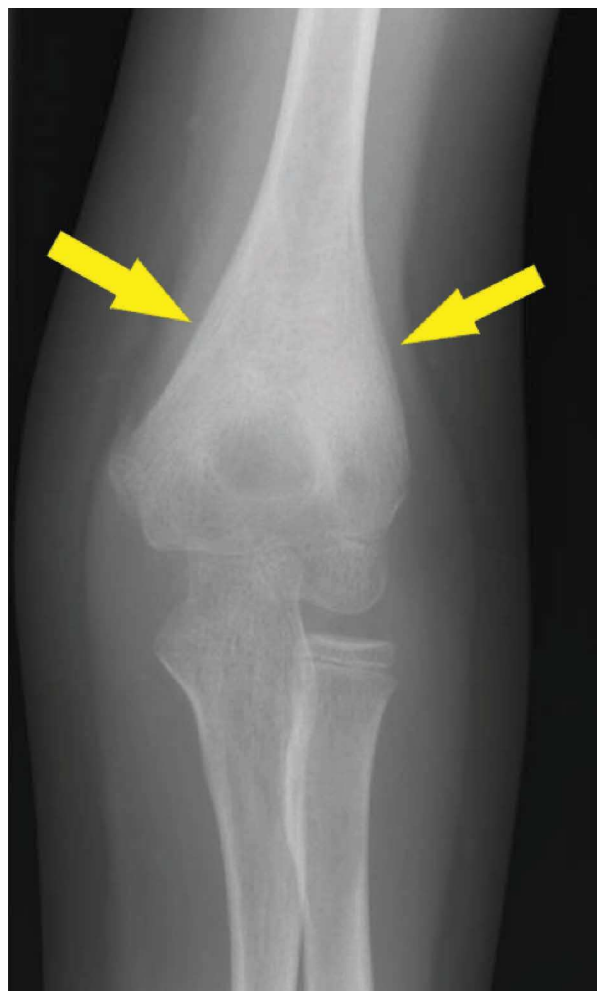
X-ray of the right elbow. The arrows show periosteal apposition on a distal humeral metaphysis.
